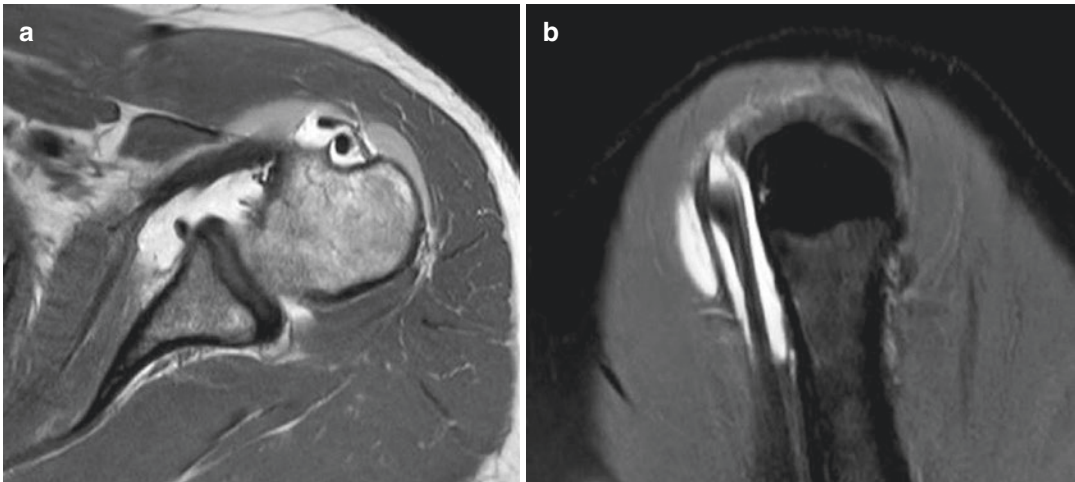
(a) Axial T2-weighted MRI scan of a biparted LHBT. (b) Sagittal T2-weighted MRI scan of a biparted LHBT
